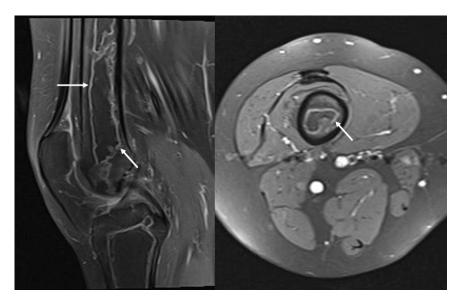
Gadolinium contrast images. Fat-suppressed T1-weighted sagittal (left) and transverse (right) images obtained after the administration of intravenous gadolinium contrast. White, serpentine bands of increased signal intensity (arrows) represent hyperemic and viable bands of granulation tissue and correspond to similar bands of increased signal intensity on the fat-suppressed T2-weighted images.
